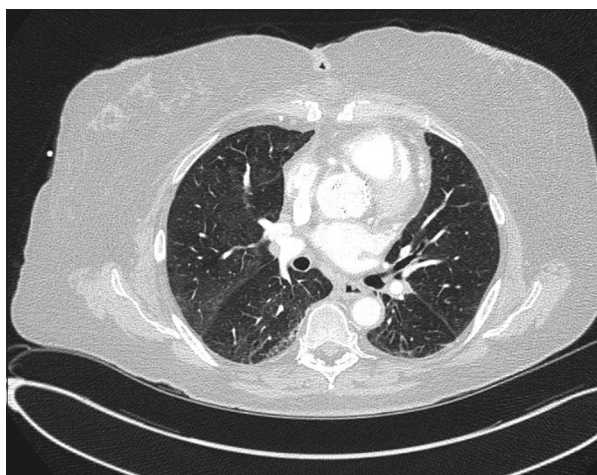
A 1-month follow-up computed tomography of the chest showed near-complete resolution with significant improvement of diffuse lung infiltrates
